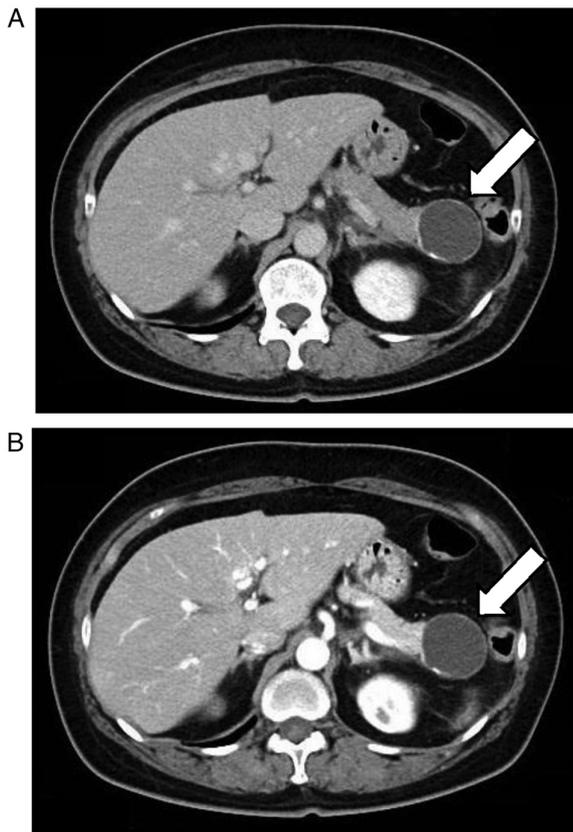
Abdominal contrast-enhanced computed tomography (A and B) A cystic lesion with calcification in the pancreatic tail (white arrows).
